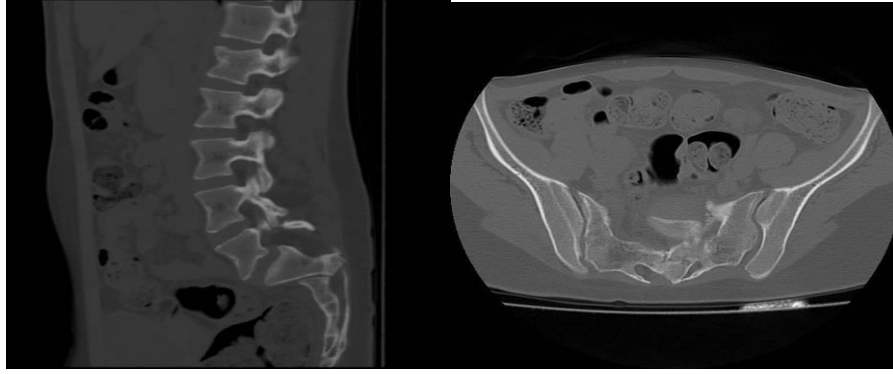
Sagittal (a) and axial CT (b) scan showing that the spinal canal is significantly narrowed secondary to anteriorly dislodged of distal sacrum, which has invaginated into the canal.
